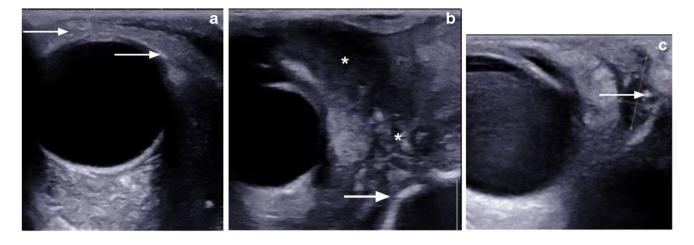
Conidiobolomycosis. The same patient as in Fig. 2. Axial ultrasonography (US) of the right orbit. a The preseptal soft tissue swelling is noted (arrow). b Extensive hypoechoic soft tissue along the medial canthus (asterisk) with intact underlying cortex (arrow).
